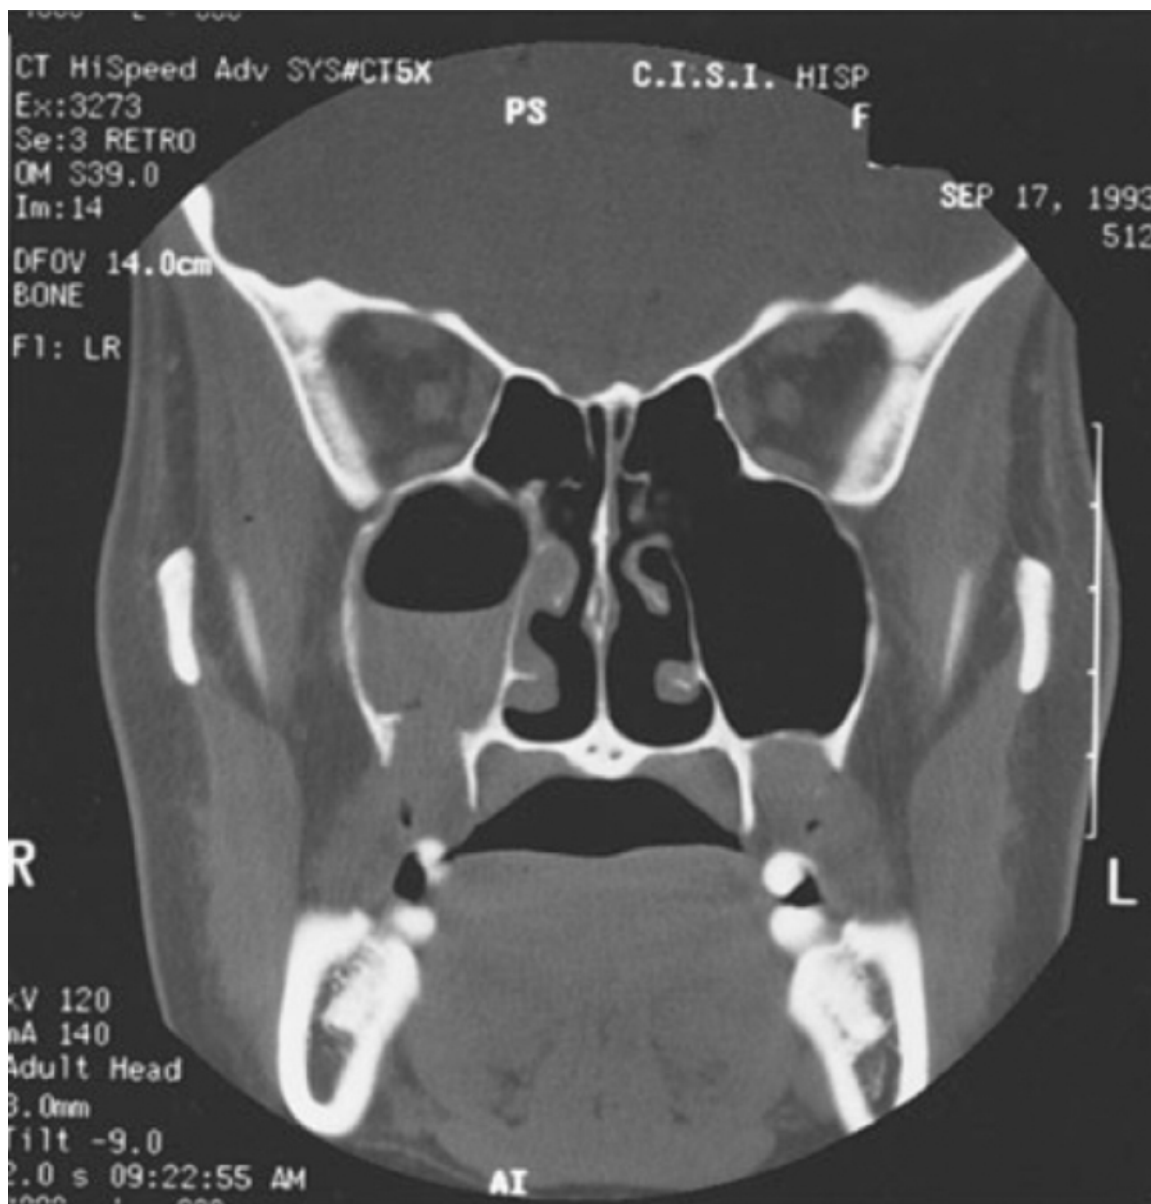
Computed tomography scan demonstrating an oral-antral fistula with obstruction of the maxillary sinus. Adequate intranasal drainage to either the middle meatus or the inferior meatus must be achieved to ensure success when the fistula is closed.
